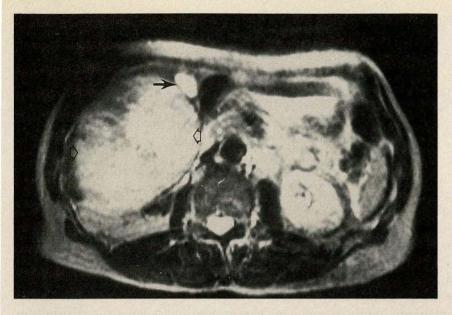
Axial T2-weighted scan demonstrates large lesion with hypointense rim comprising most of hepatic volume, representing hepatoma (open arrows). Arrow indicates gallbladder.
